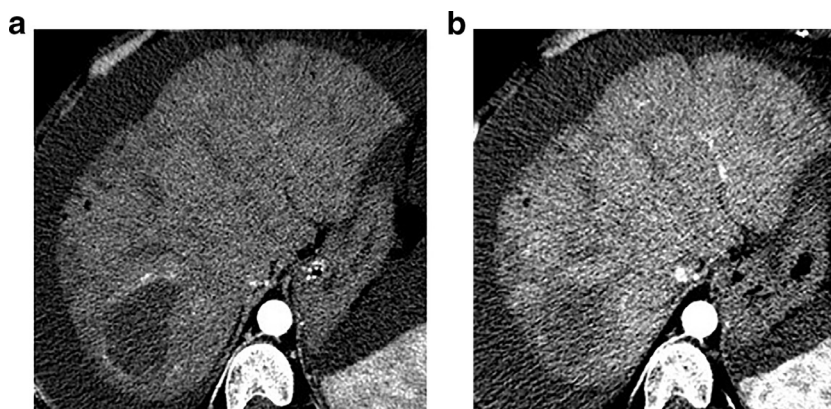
a,b – Post TACE axial ceCT scan in arterial phase A. after 1 month shows complete absence of enhancing of the liver lesion; B. confirmed on CT scan after 3 months from TACE.
